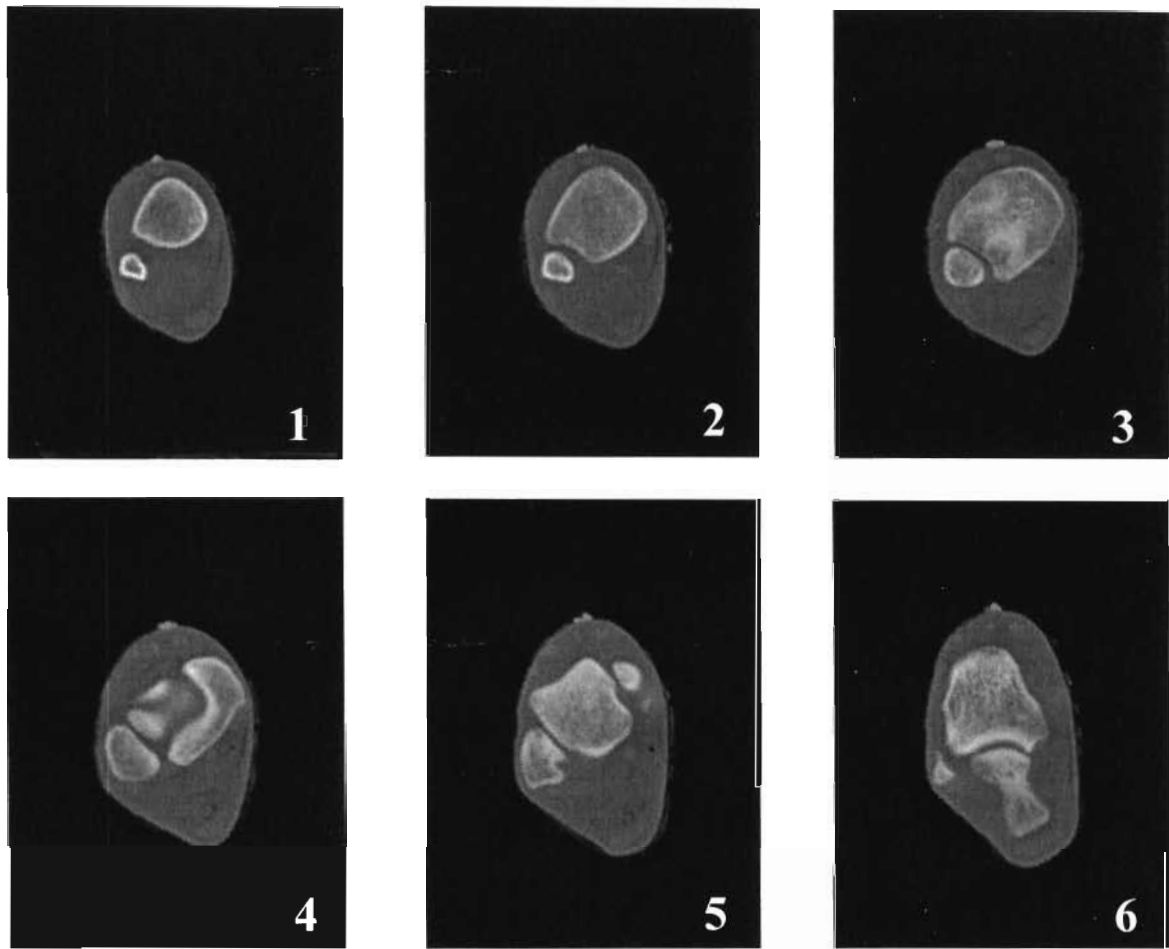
DICOM Images from the Visual Human Project: These are close-ups of the right ankle with the distal articulation of the tibia and fibula coming into view (top row figs 1-3). Later, the talus and calcaneus appear in the images (bottom row figs 4-6). Scans are shown in 10mm increments. (Note: CT scans look from the inferior up, therefore right of the scan is actually the left and vice versa)
